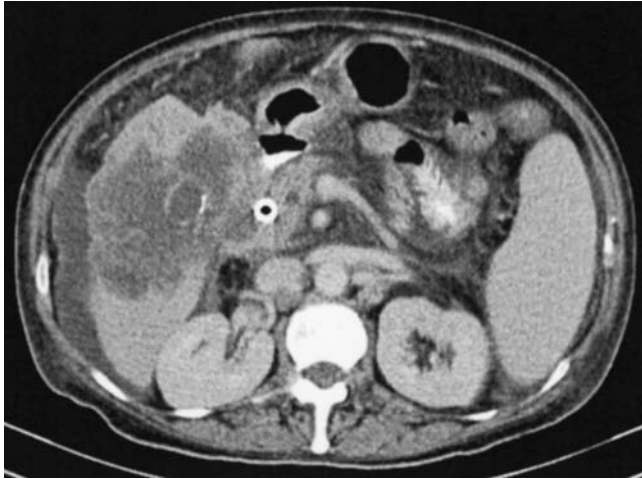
CT scan of advanced gallbladder cancer. The image demonstrates an advanced gallbladder cancer with extensive liver invasion. A stent has been placed for palliation of obstructive jaundice.
